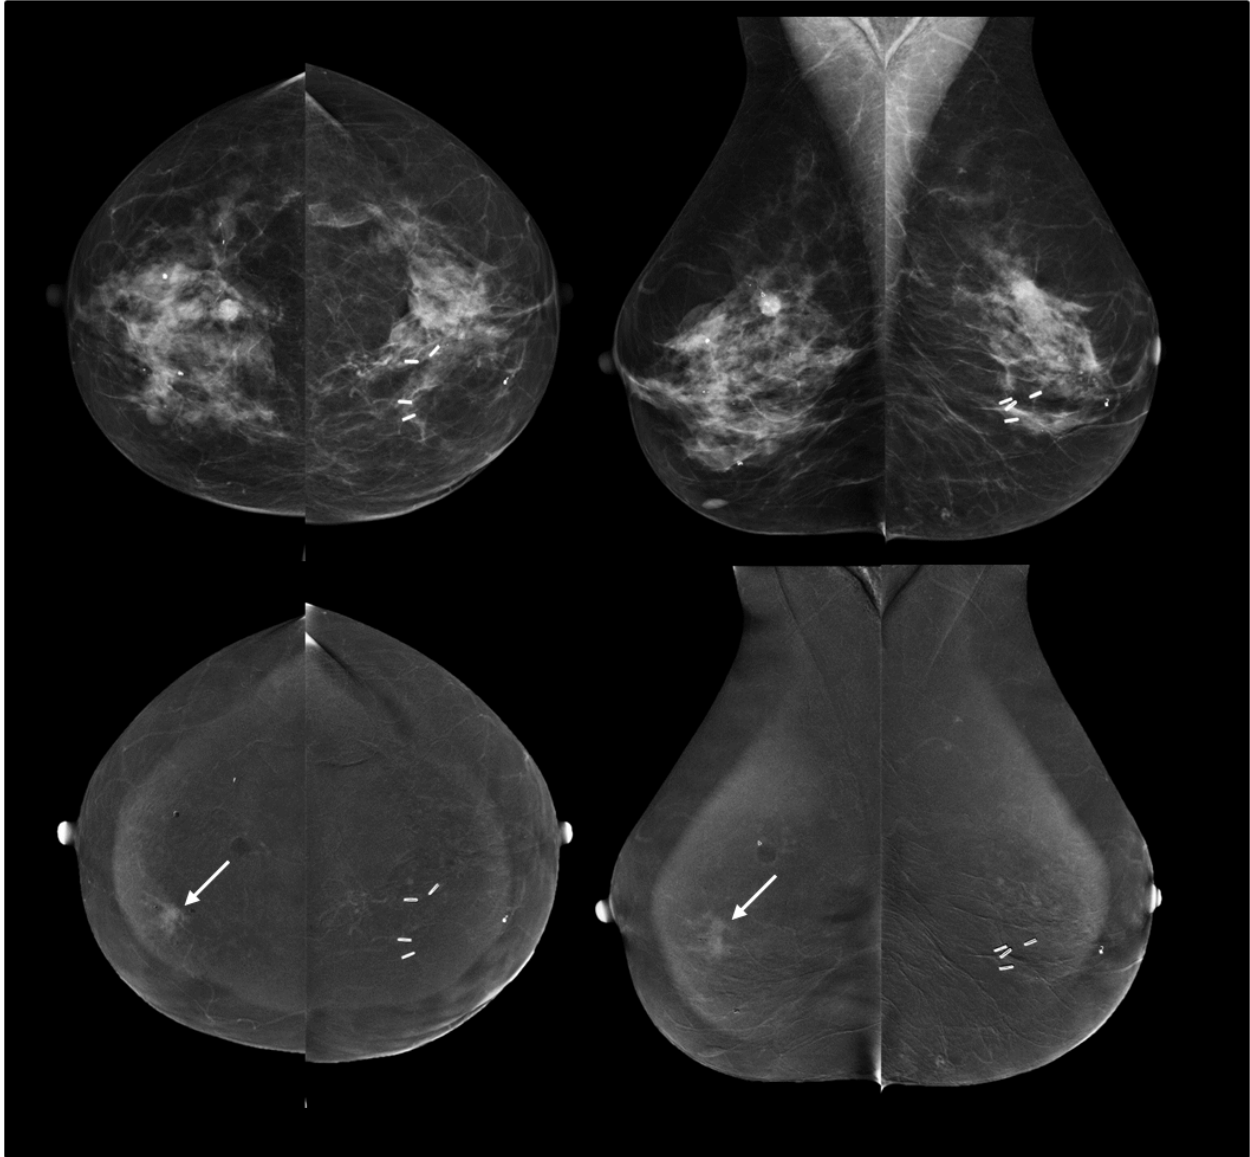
High-risk screening CEDM. 57-year-old woman with high lifetime risk of breast cancer due to family history. Standard digital mammograms (upper images) show heterogeneously dense parenchyma, benign-appearing round mass upper right breast and surgical clips left breast. Patient chose to undergo CEDM (lower images) instead of MRI due to high out-of-pocket costs with MRI. Non-mass enhancement is seen in the right breast at 4 o'clock (arrows). Biopsy of an US correlate showing fibrocystic changes was considered discordant. Excisional biopsy showed high grade DCIS. *Images courtesy of Jennifer Harvey, MD.*
